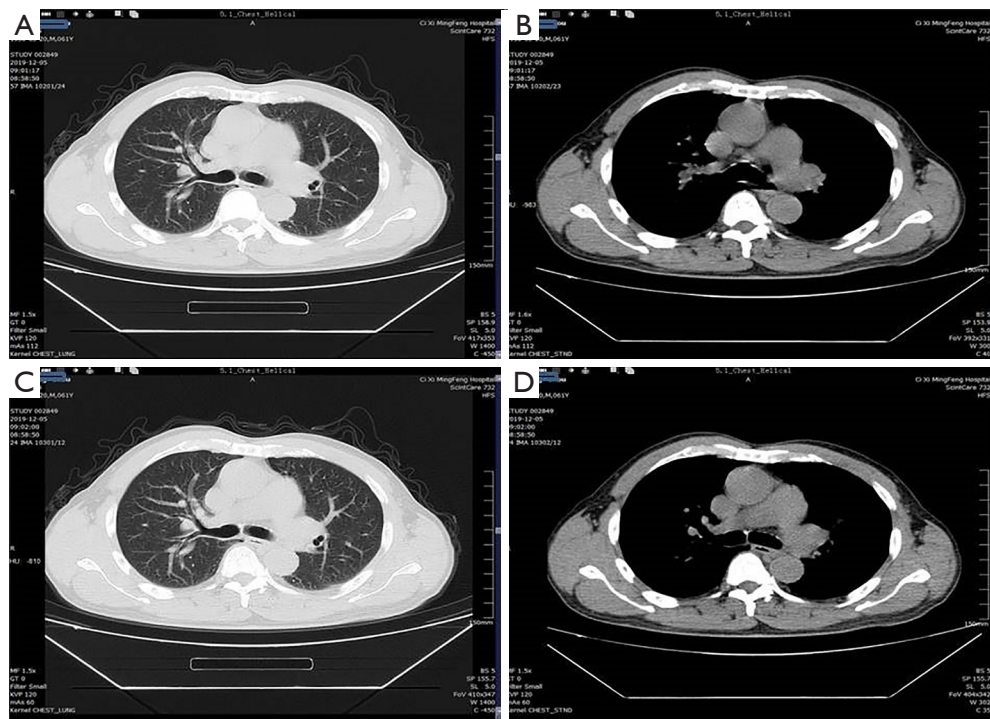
CT Chest image comparison at different radiation doses in the same volunteer subject. The upper panels represent the conventional dose (120 kV, 110 mAs) and the lower panels are the NDI reconstruction at a low dose (120 kV, 60 mAs).
